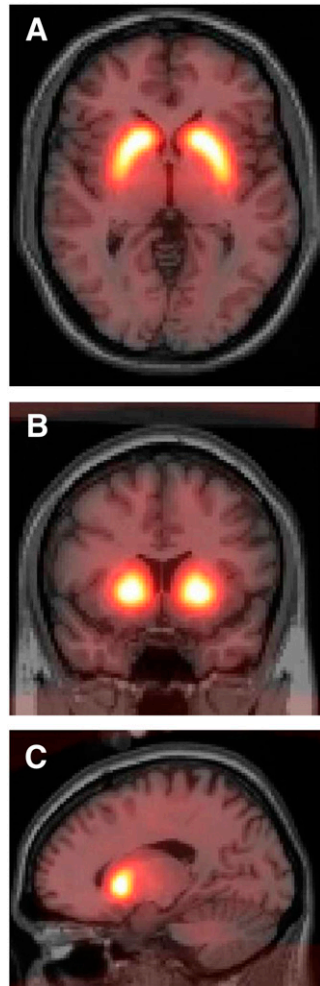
Template A1 overlaid on single-subject brain MRI available in SPM in 3 orthogonal views: A, axial; B, coronal; and C, sagittal. Normalized striatal ^{123}I -FP-CIT binding is accurately superimposed onto striatum.
